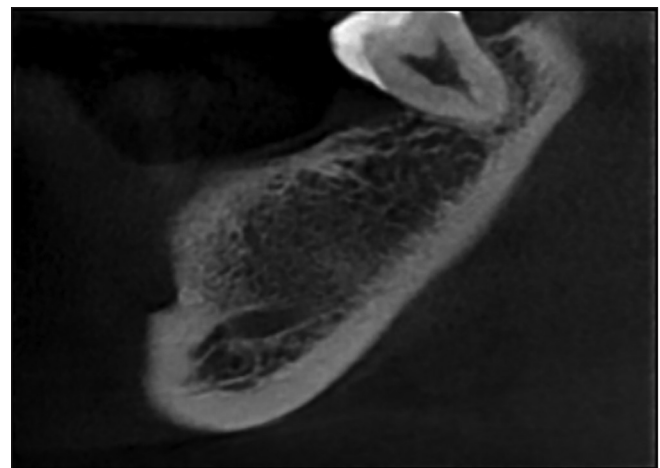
Cone beam computed tomography image of sagittal view of C-shaped canal
